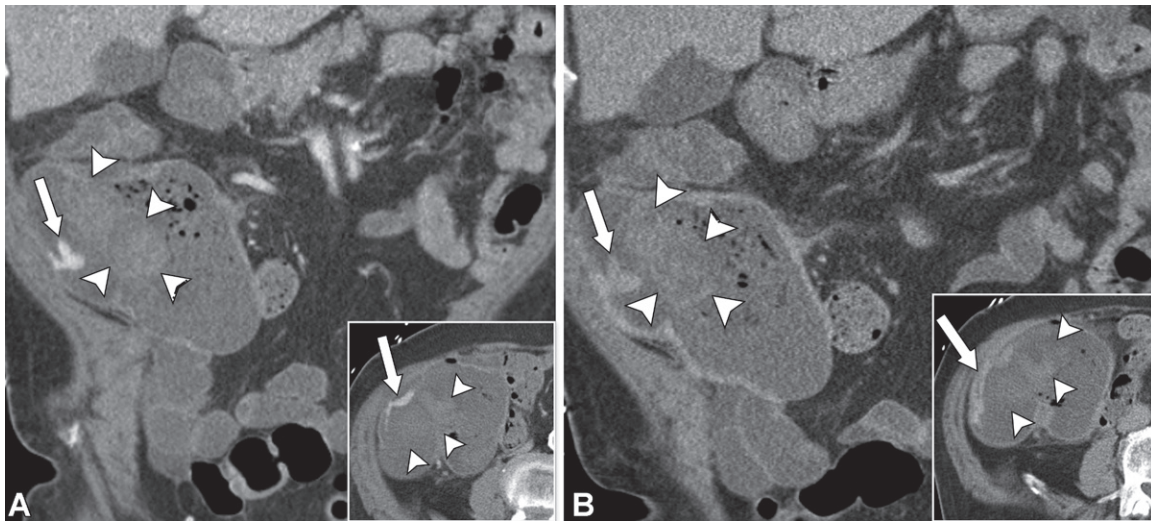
Colon carcinoma with active bleeding in an 84-year-old man with a supratherapeutic international normalized ratio who presented with bright red blood in the rectum and intermittent hypotension. Arterial phase coronal (main image) and axial (inset) (A) and delayed phase coronal (main image) and axial (inset) (B) CTA images show contrast extravasation in the arterial phase (arrows in A), which changes in size, attenuation, and shape in the delayed phase (arrows in B). Also noted is a heterogeneous mildly enhancing mass in the ascending colon (arrowheads in A and B). Subsequent colonoscopy showed an ascending colon mass that was confirmed to represent an adenocarcinoma at surgical pathologic examination. (Reprinted, with permission, from reference 4.)
